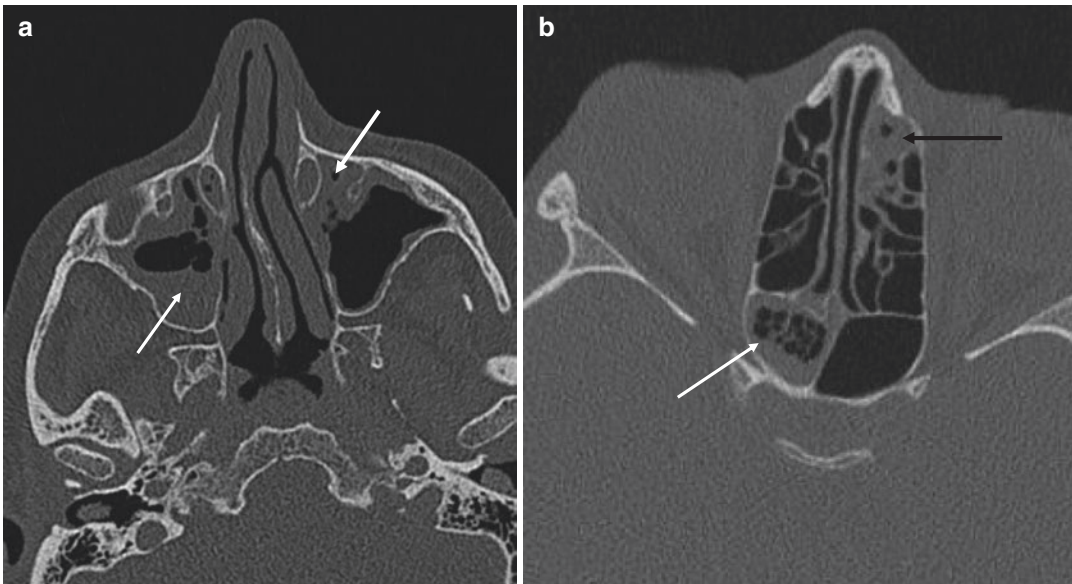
Axial CT in an adult male with acute uncomplicated sinusitis. There is partial opacification of both maxillary sinuses (white arrows in image a) including an air-fluid level and bubbly secretions on the right. At a
